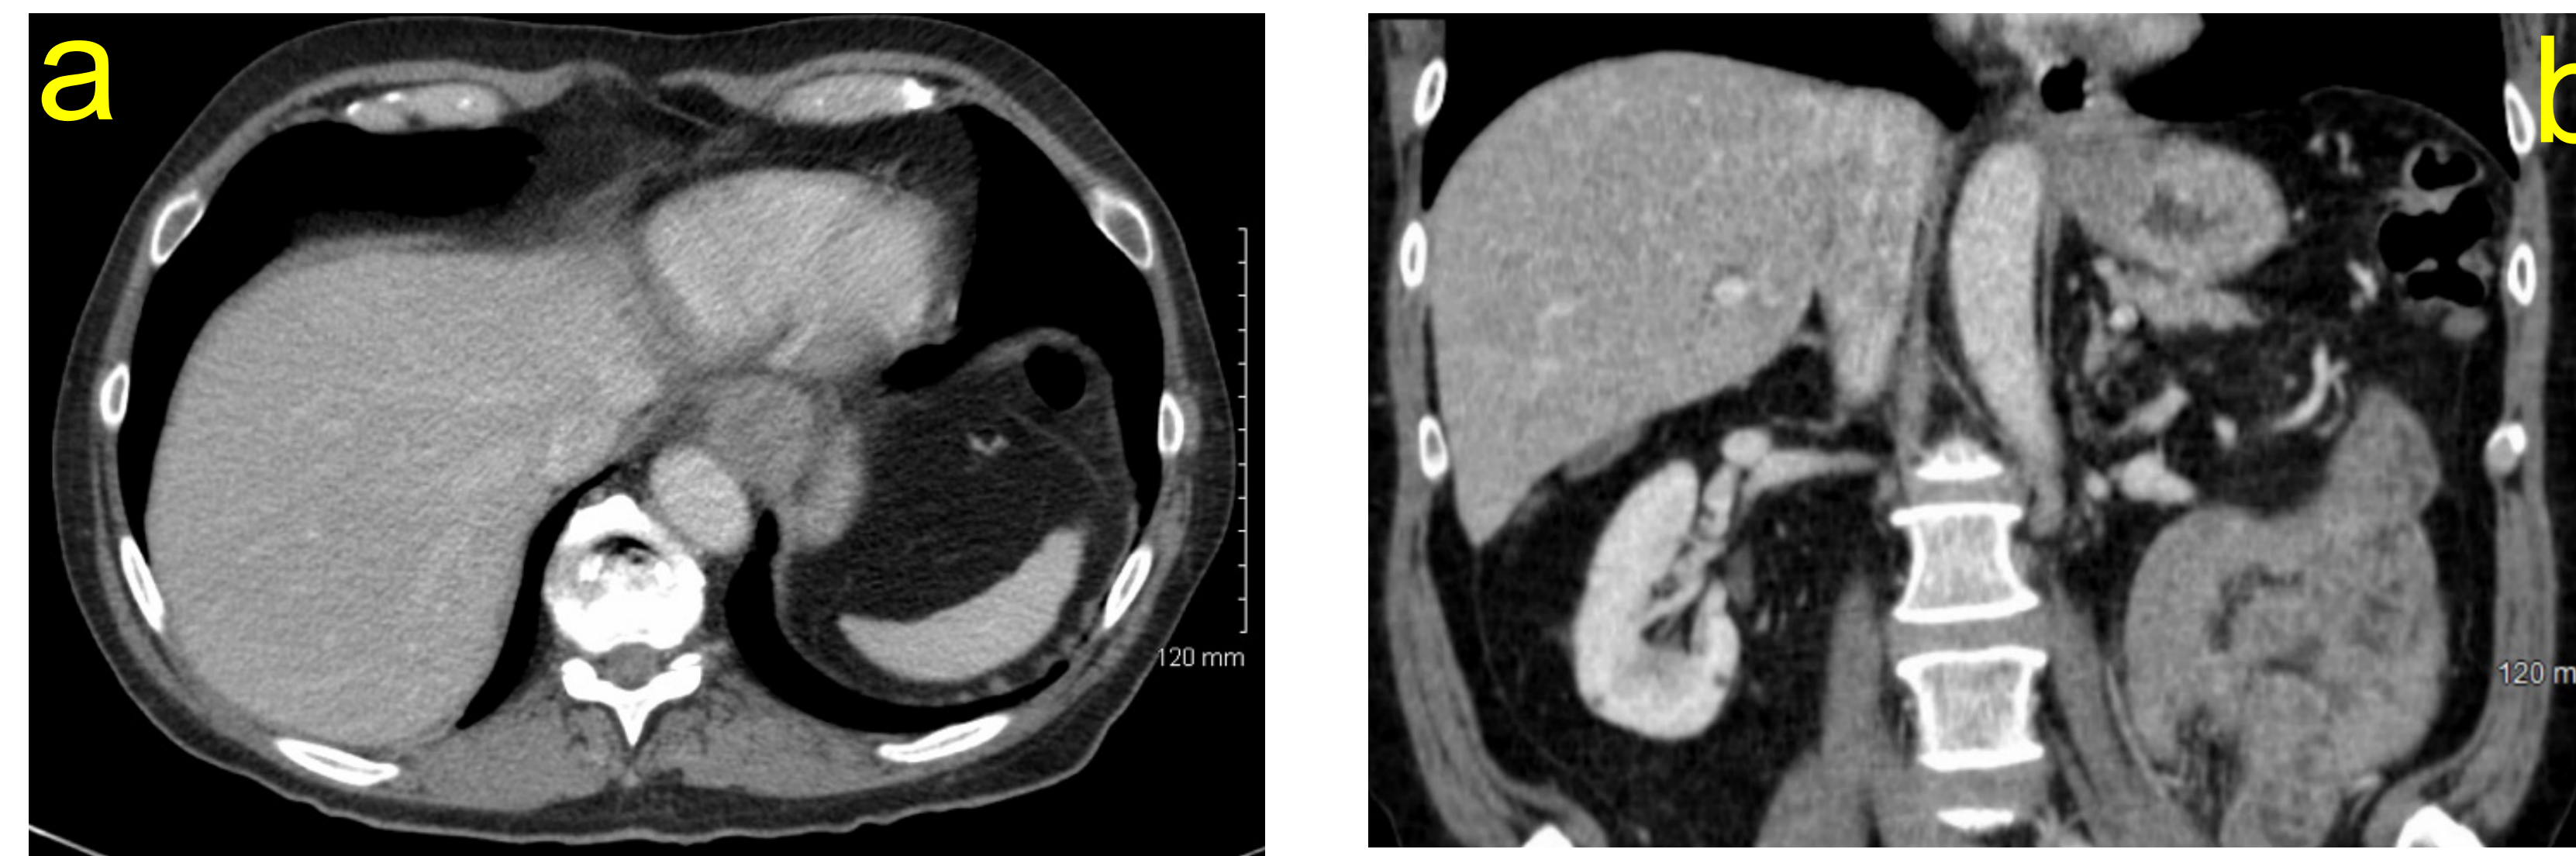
Computed tomography (CT) scan of the abdomen revealed hypoattenuating infiltrative lesion in the gastroesophageal junction (GEJ), axial image (a) and coronal (b)
